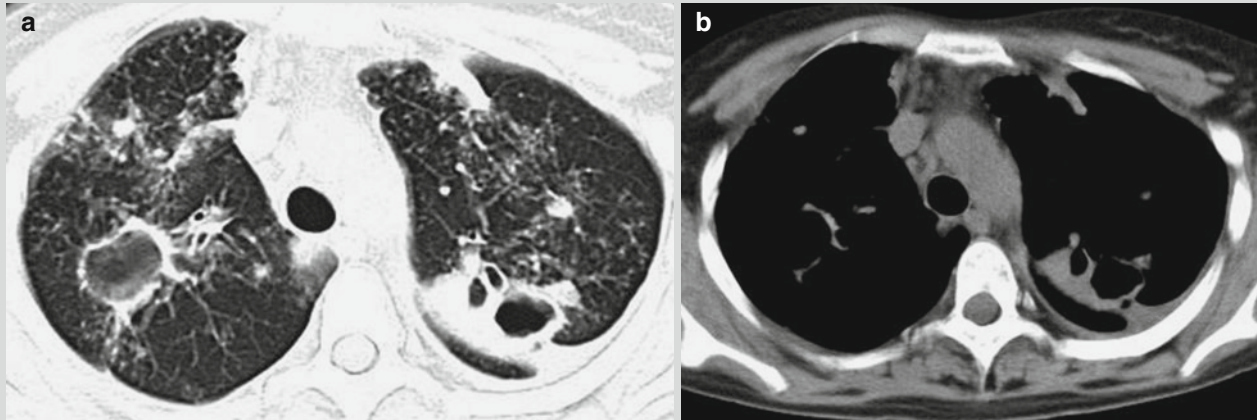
Infiltrative pulmonary TB and pleural effusion. (a, b). CT scanning demonstrates multiple thick wall cavities in different sizes at both upper lung lobes, uneven thickness of the thick wall cavities, multiple small patches and cotton wool like shadows
